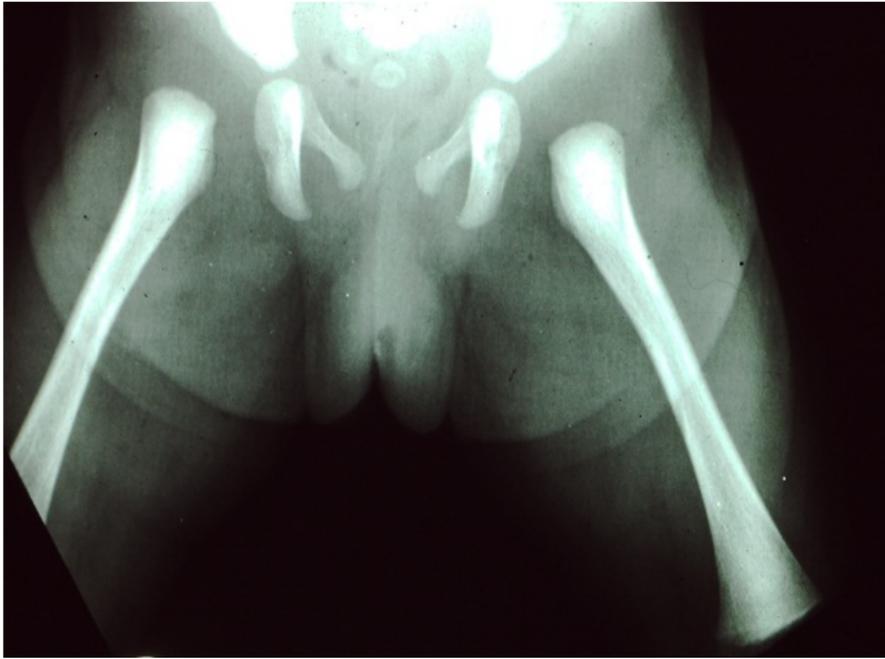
Provoked x-ray subluxation of right hip on day 1(6).
